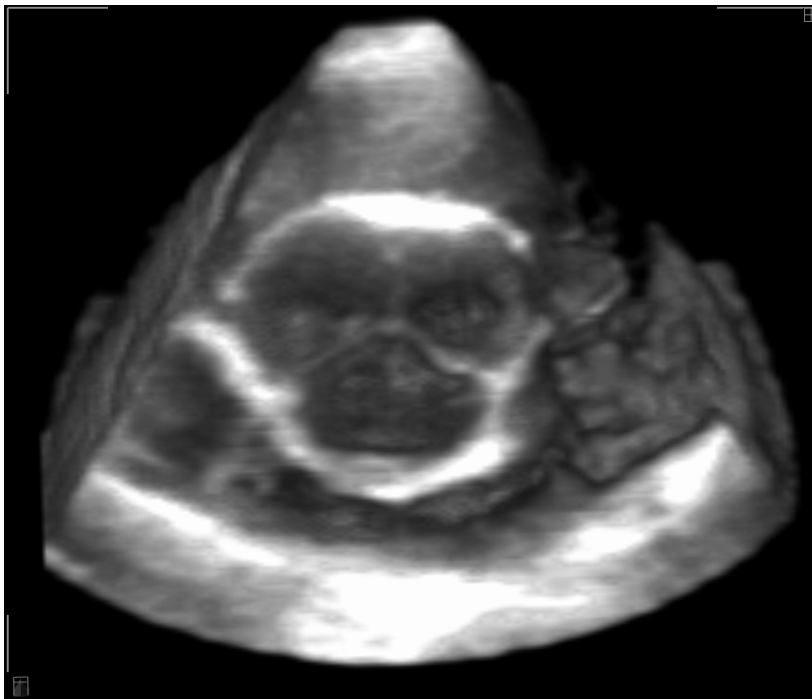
Real-time 3-D echocardiographic image of the aortic valve. The aortic valve is visualized from above with electronic aortotomy.
